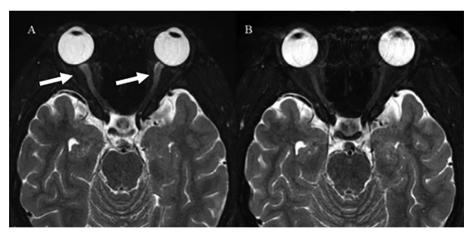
T2 magnetic resonance image showing swelling in both optic nerves pre-treatment (A) and reduced swelling post-treatment (B).
